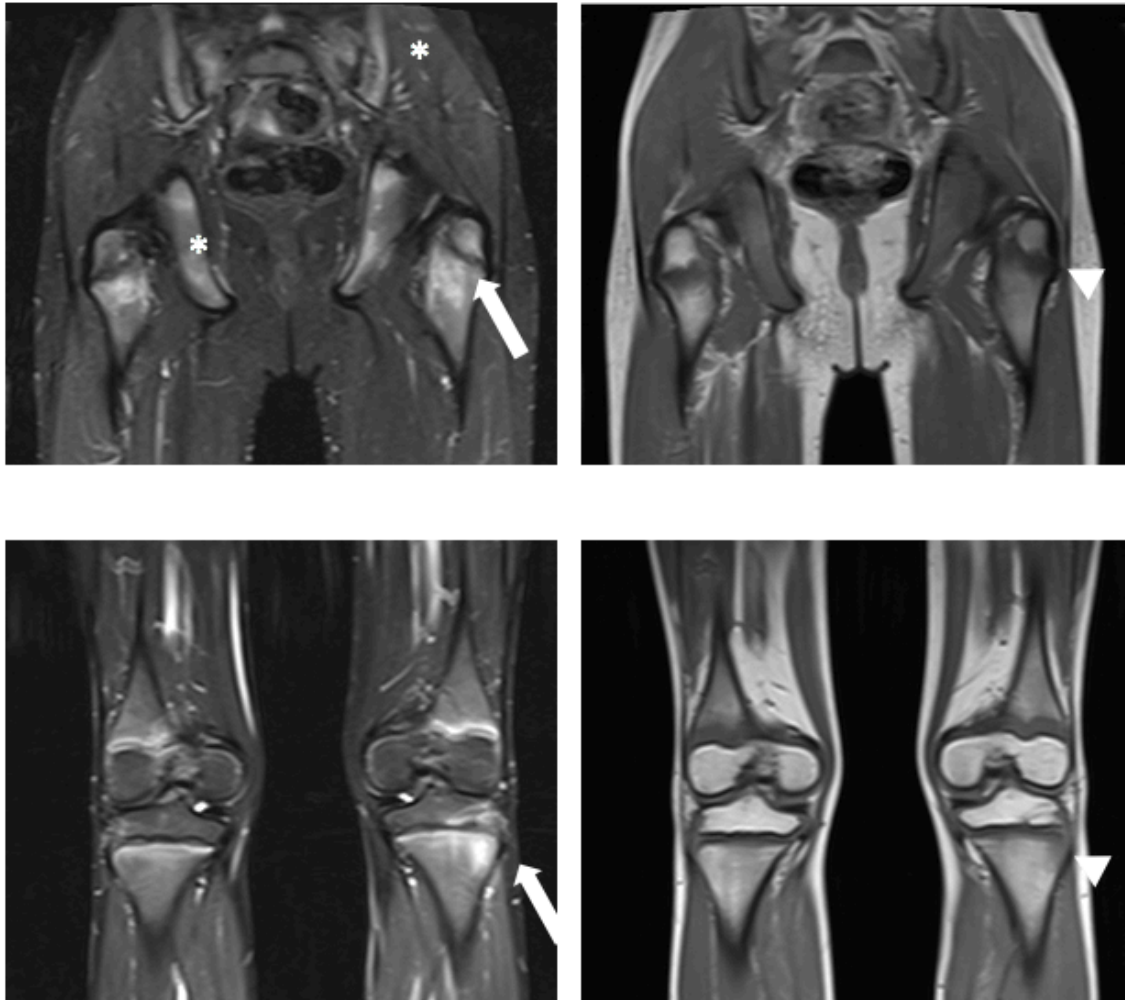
Coronal MRI images of the pelvis/proximal femur, distal femur and proximal tibia. There is edema at the at periphyseal regions of the femur and tibia on short-tau inversion recovery (STIR) images (white arrows). Corresponding low signal changes noted on T1-weighted (T1W) images (arrowheads). Similar asymmetric involvement of the pelvic bones and sacroiliac joints (*). The imaging findings are most concerning for CRMO given the clinical context.
